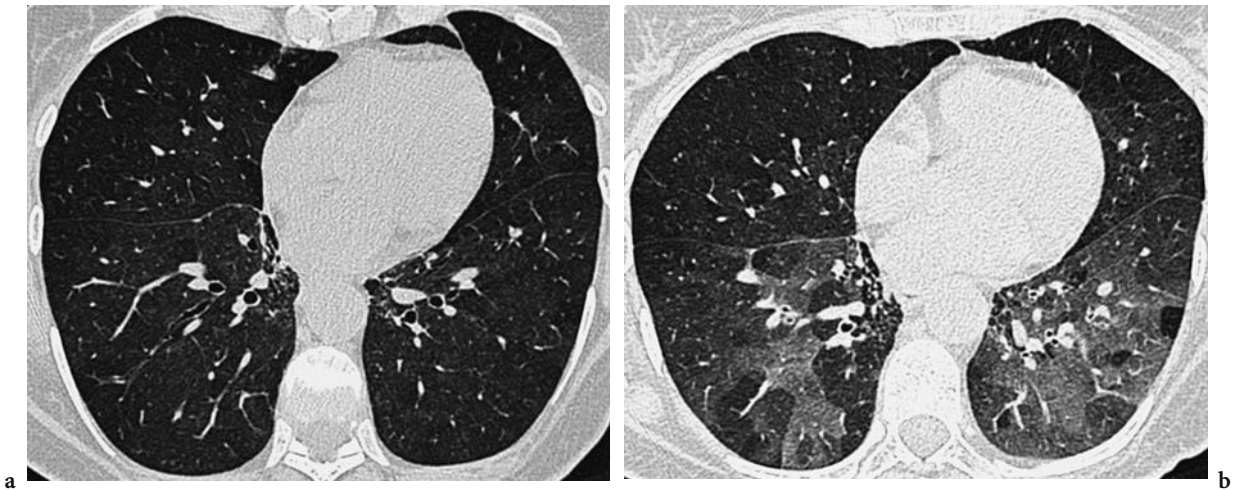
Thin-section computed tomography images obtained on inspiration (a) and expiration (b) in a 52-year-old farm worker. There is a suggestion of a mosaic attenuation pattern on the inspiratory image, but the appearances are far more striking on the expiratory image, with focal areas of air-trapping
